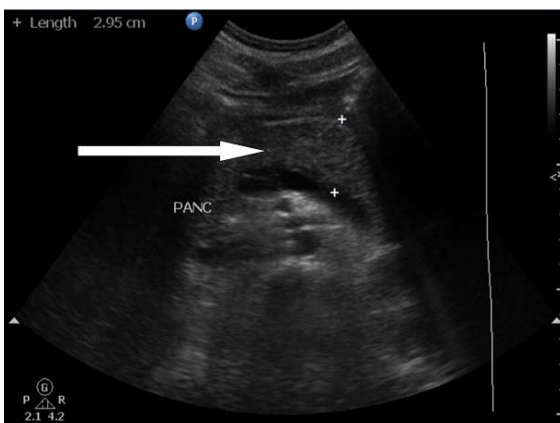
Ultrasound abdomen with edematous pancreas
